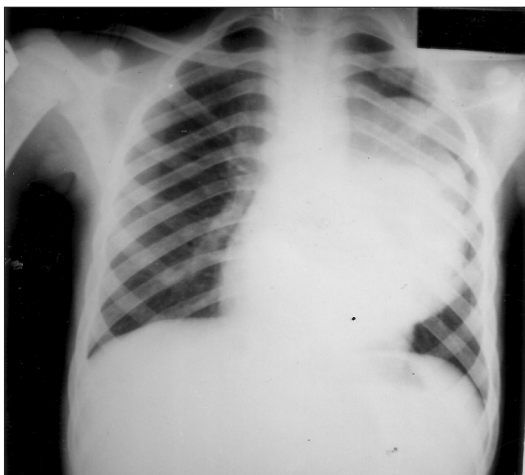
Postero-anterior chest radiograph of the patient in Figure 1 showing a large soft tissue mass overlying the left upper lobe and the left cardiac border
